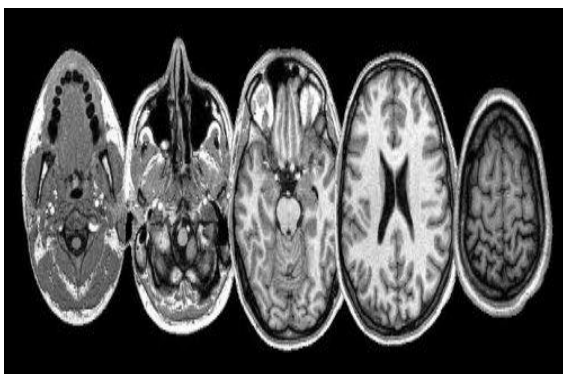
Image created using MRI technology.
